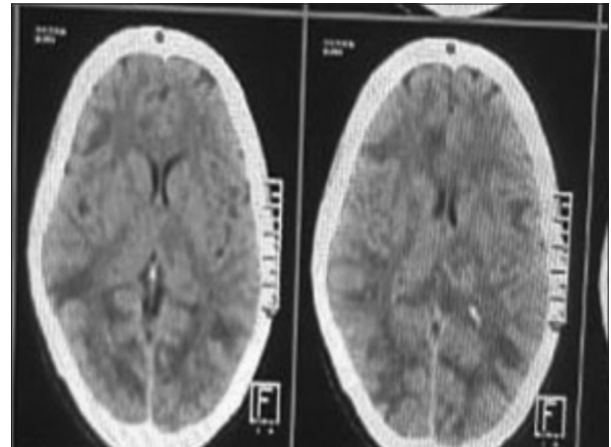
Non-contrast computed tomography brain showing multiple ring-enhancing lesions with surrounding edema
